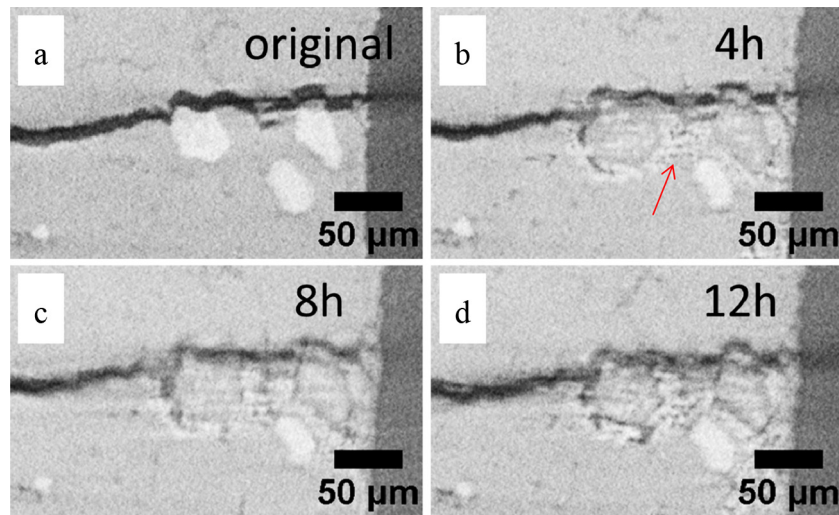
2D X-ray tomographic cross sections with surface breaking Cr particles at different healing stages: (a) original; (b) after 4 h healing at 1200 °C in air; (c) after 8 h healing at 1200 °C in air; (d) after 12 h healing at 1200 °C in air.
